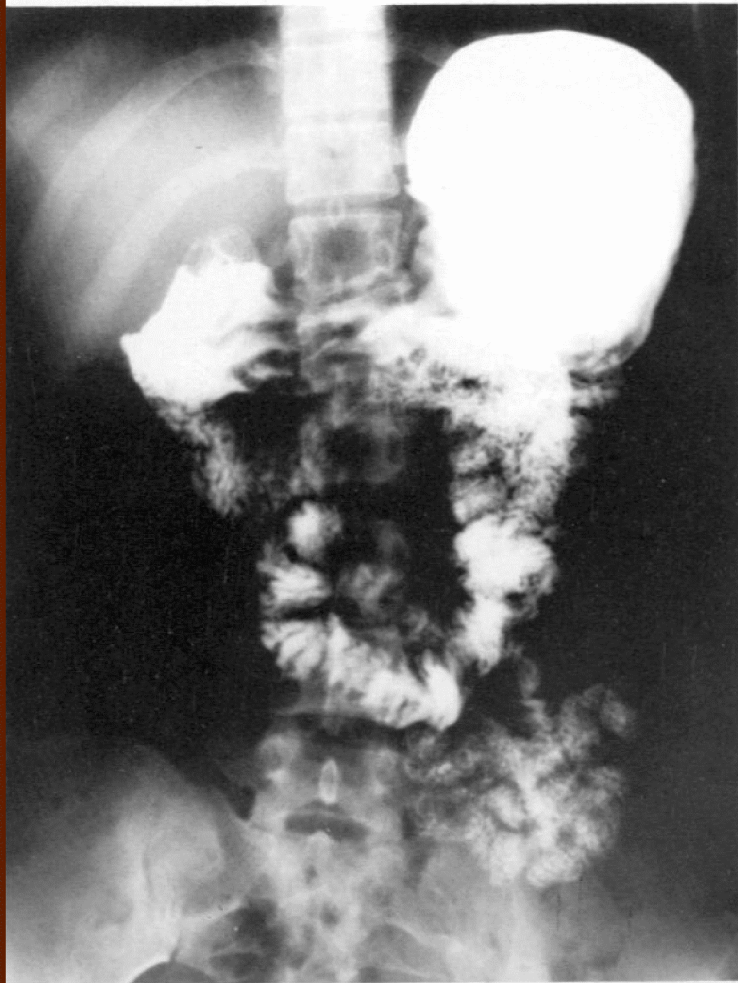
Immediate radiograph.
